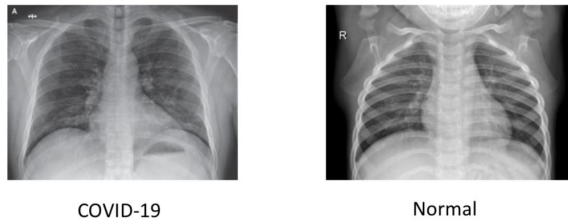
Normal and COVID-19 Chest X-Ray Images.
